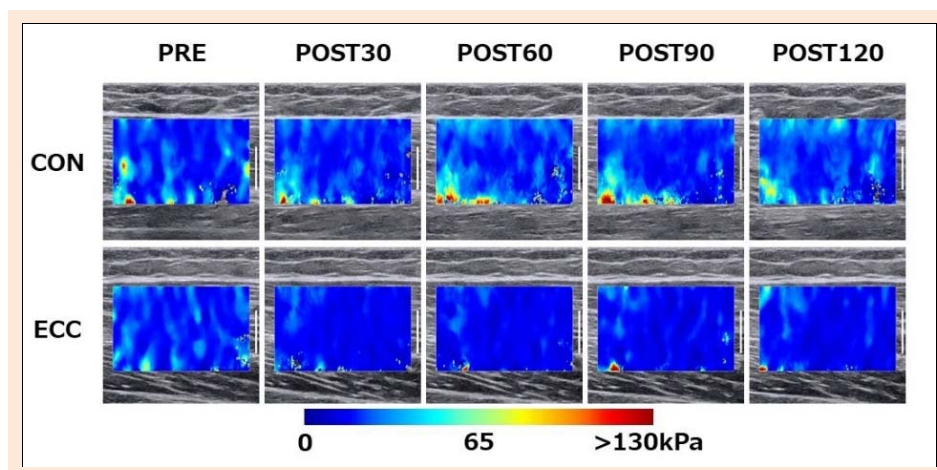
Typical examples of ultrasound shear wave elastography measurements of the biceps femoris long head (BFlh) in concentric (CON) and eccentric (ECC) tasks. Measurements were performed before (PRE) and 30, 60, 90, and 120 s after each task (POST30, POST60, POST90, POST120, respectively). The colored region represents the shear modulus map with the scale below the images. Scale bar = 1 cm.
